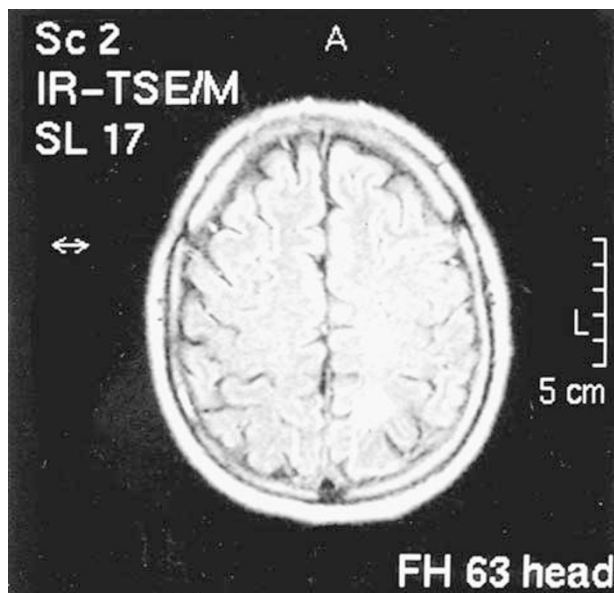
Axial FLAIR sequence MRI of the brain shows high signal area at the left parieto-occipital boundary. Appearance suggests ischaemia.
